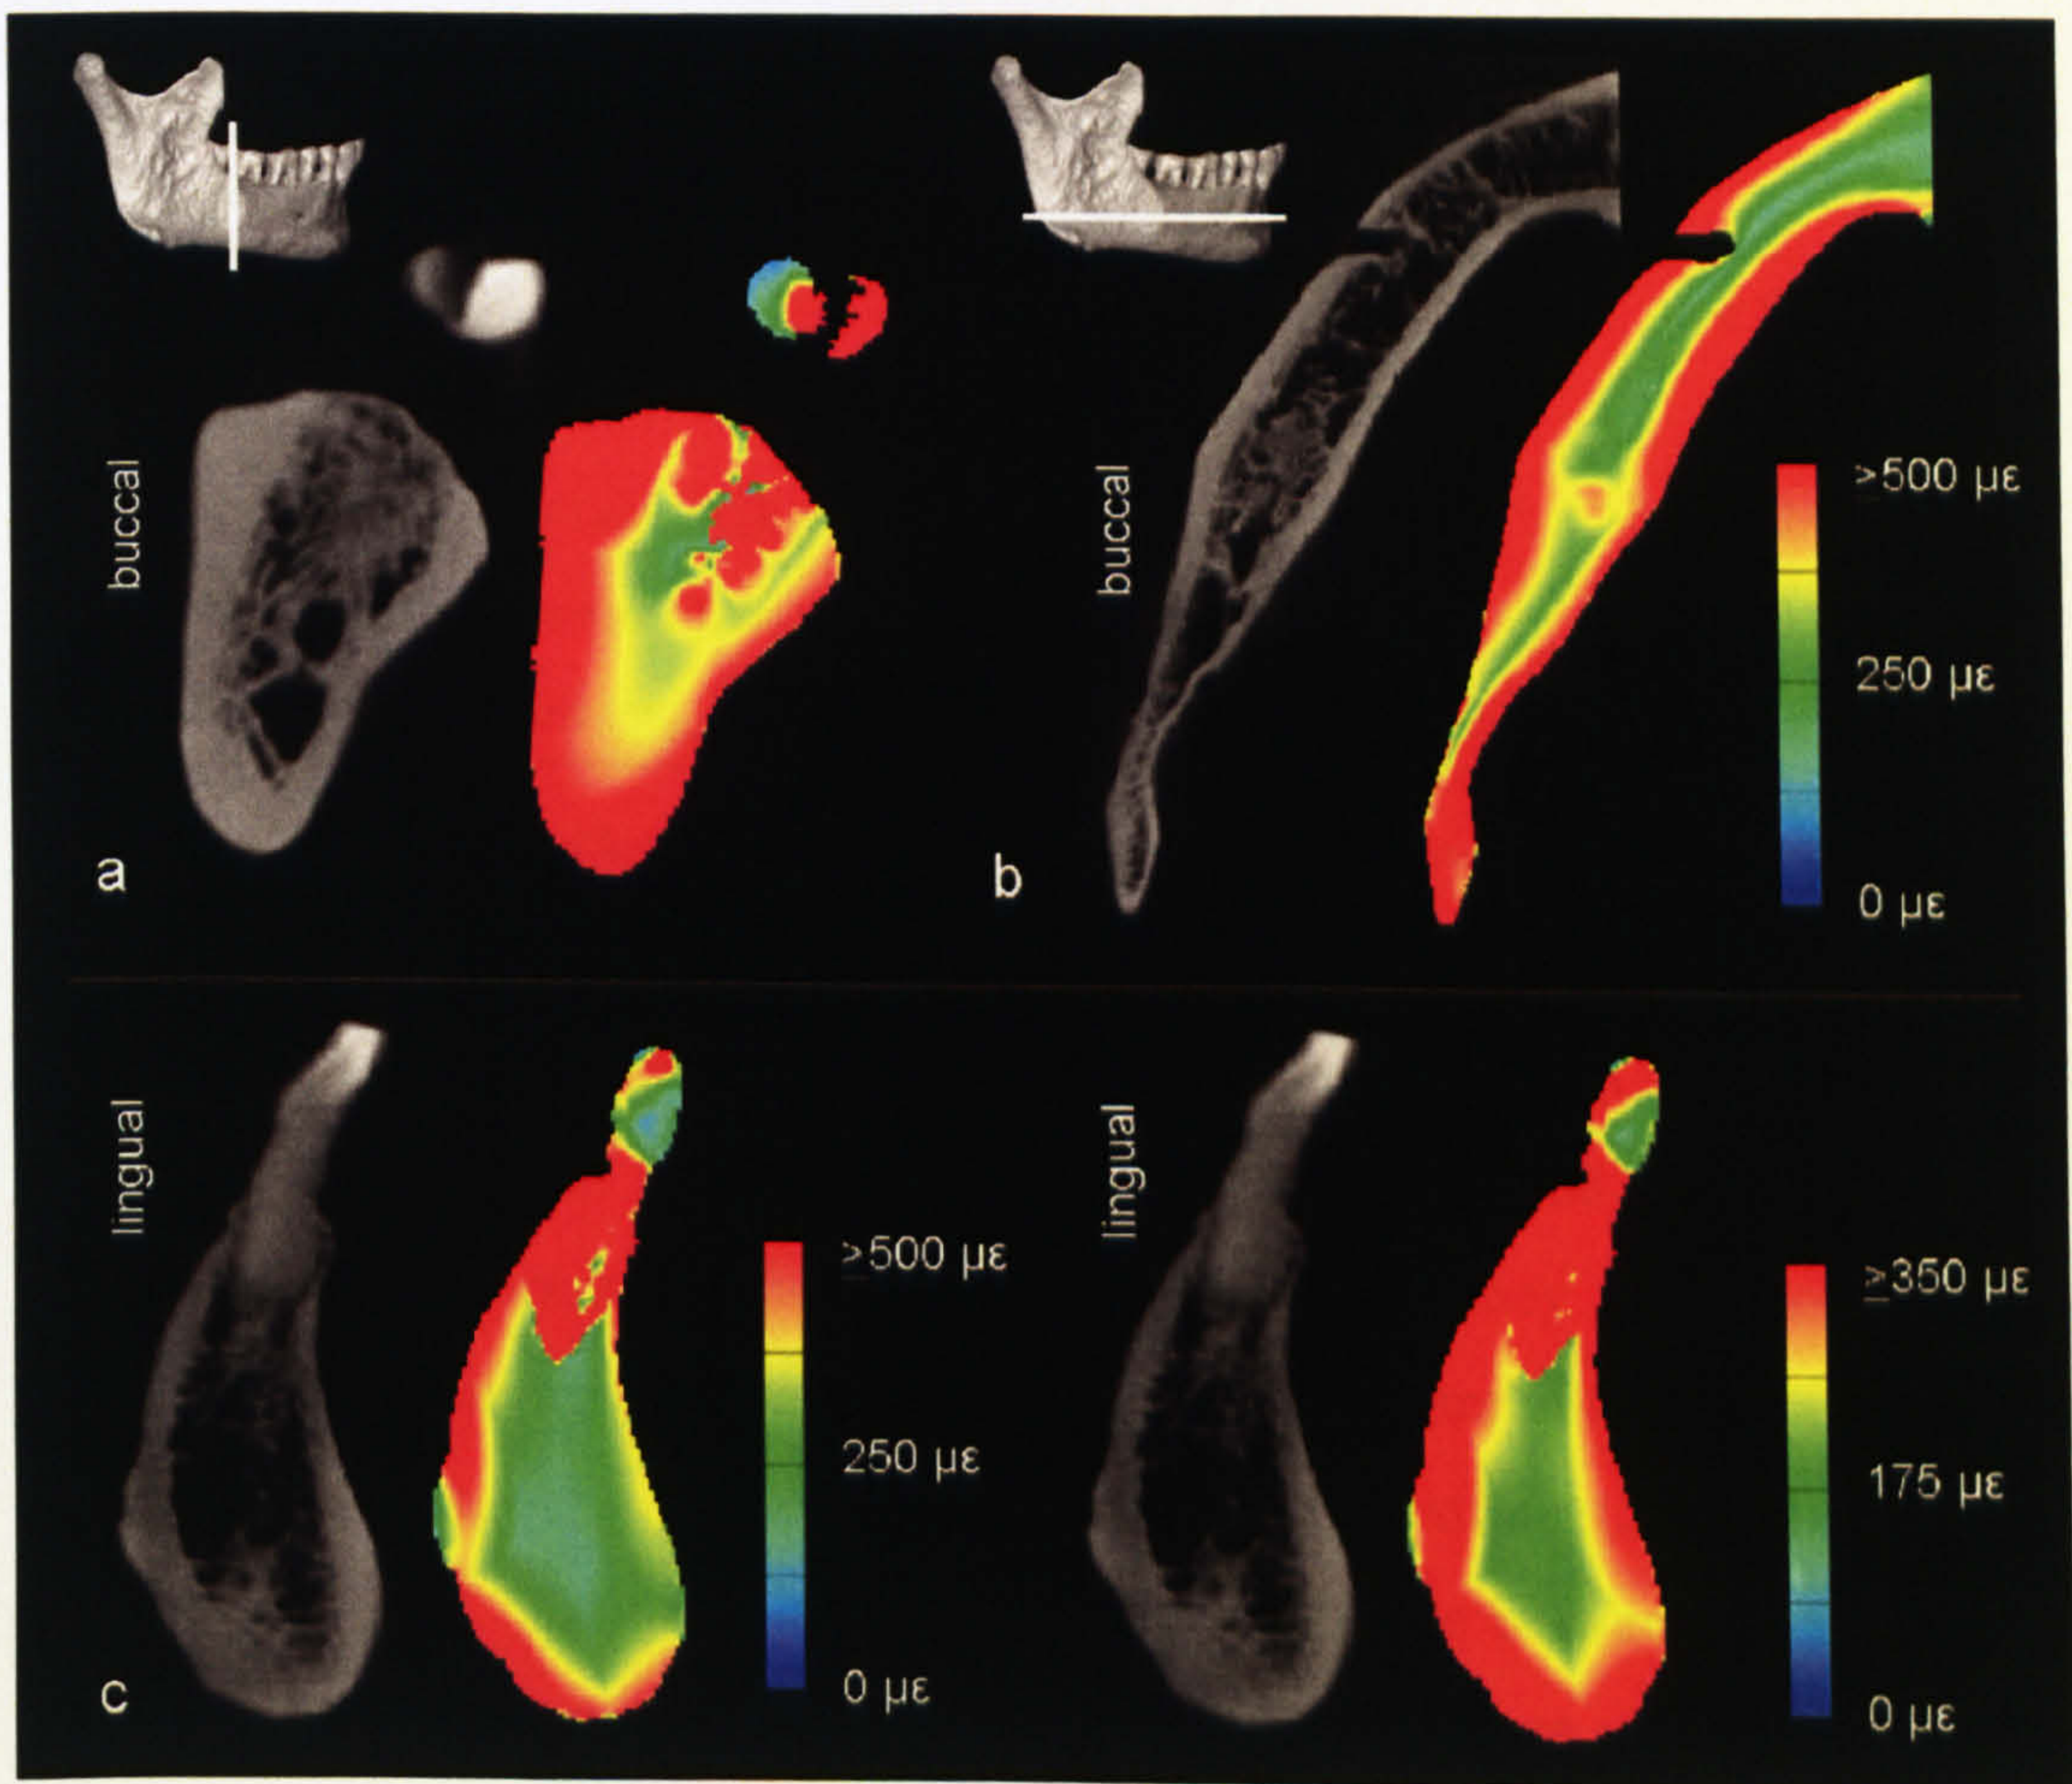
Comparison between CT slices and corresponding slices through the filled FE model with von Mises strain (ϵ_v) contour plots: a) coronal section through the posterior corpus between M2 and M3, b) transverse section through the mental foramen, c) mid-sagittal sections through the symphysis. Note that two different colour ranges are used to visualise the strain distribution in the symphysis.
